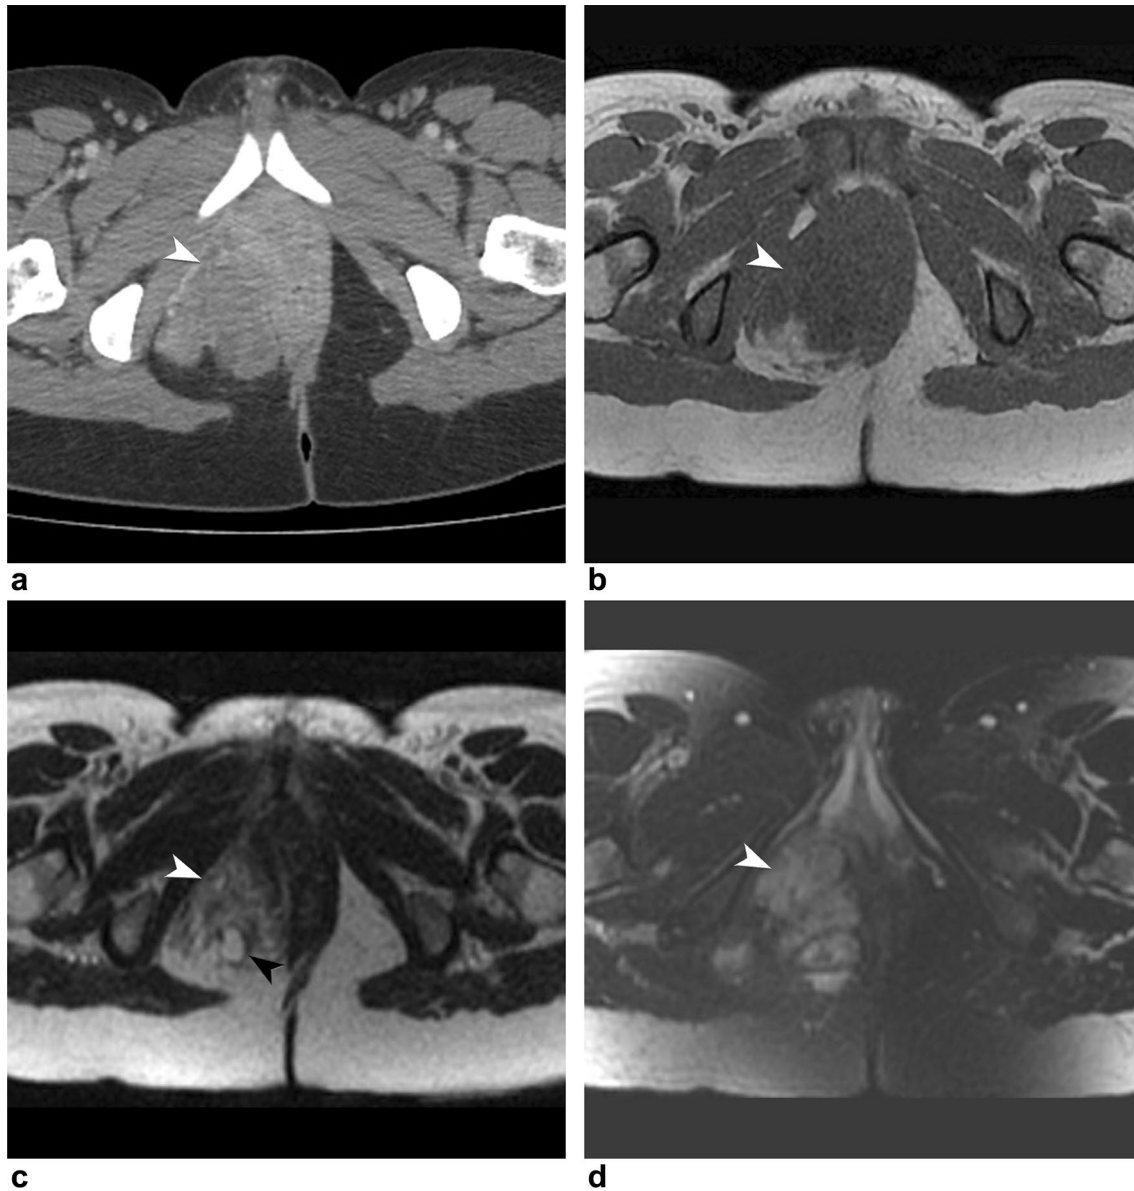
34-year-old female presents with nausea and bloating for which an abdominal ultrasound was performed and revealed a pelvic mass. She underwent CT and MRI for further assessment. a Axial contrast-enhanced CT image of the pelvis showing a 6.6 cm mass in the right ischiorectal fossa (white arrowhead) with heterogeneous contrast enhancement. b–d Pelvic MRI, Axial T1WI (b), T2WI (c)
